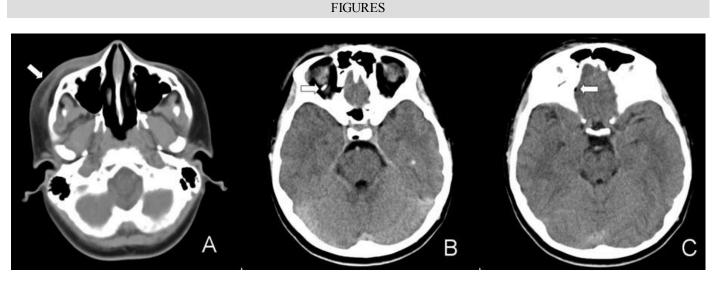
13-year-old male with comminuted right orbital roof "blow-in" fracture. Initial unenhanced CT head (obtained with a Siemens SOMATOM® Definition AS 128-slice CT scanner, Siemens Healthcare; axial acquisition of 0.6 mm thickness over the area scanned with subsequent reconstruction into 5 mm contiguous axial scans of 5 mm thickness; 120 kV; 425 mAs; Total Dose: 1.15 Gy) demonstrates (a) soft tissue swelling in the right infraorbital region anterior to the maxillary sinus and right zygomatic arch (arrow) on soft tissue window settings, (b) abnormal bone density (arrow) in the superior, posterior right orbit on brain window settings, and (c) retrospectively identified abnormal focus of intracranial air (arrow) in the anterior cranial fossa on brain window settings.
